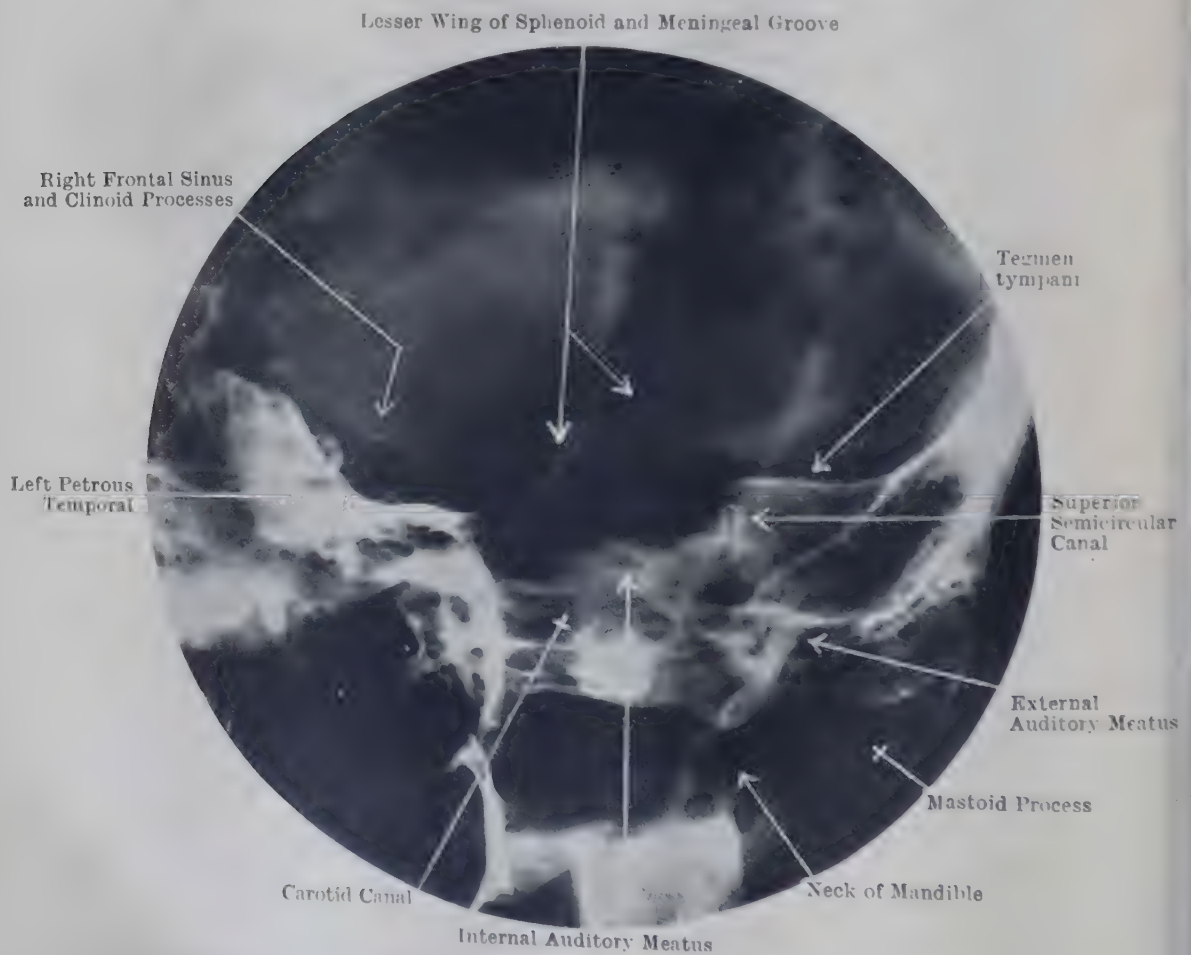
RADIOGRAPH OF SKULL SHOWING SOME DETAILS OF THE TEMPORAL BONES (Stenver's projection).
